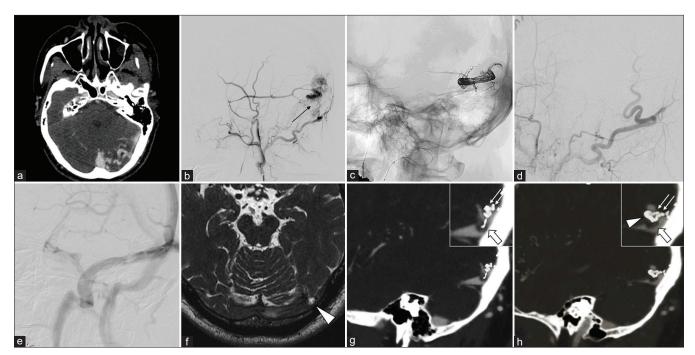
(a) Contrast-enhanced computed tomography (CT) demonstrates cortical venous reflux, indicating a left transverse-sigmoid dural arteriovenous fistula (DAVF). (b) Left external carotid artery angiography (lateral view) demonstrates multiple feeding arteries of a DAVF from the petrosquamous branches of the middle meningeal artery (MMA) and transosseous branches of the occipital artery (OA) directly draining into the cortical vein. The shunting point was suspected to be limited to the transverse sinus (TS) wall with no venous drainage into the dural sinus (black arrow). (c) Transarterial Onyx embolization was performed through the petrosquamous branch of the MMA with a DeFrictor microcatheter (Medico's Hirata, Osaka, Japan) and achieved successful penetration into the cortical vein. A Scepter C (Terumo, Tokyo, Japan) 4×10-mm balloon catheter was placed and inflated on the proximal side of the OA, with flow reduction during Onyx injection. (d) Final view after Onyx embolization; complete occlusion of the arteriovenous shunt. (e) The venous phase of internal carotid artery angiography demonstrates that left the TS was intact with no Onyx penetration. (f) Heavy T2-weighted magnetic resonance imaging before Onyx embolization demonstrates the existence of arachnoid granulation (AG) in the shunting point of the left TS (white arrowhead). (g and h) The sagittal view of postoperative digital subtraction angiography and CT fusion image shows that the Onyx cast demonstrated that multiple feeders (white arrows) aggregated into the AG (white arrow) and a dilated draining vein launched from the shunt point (white arrowhead).
